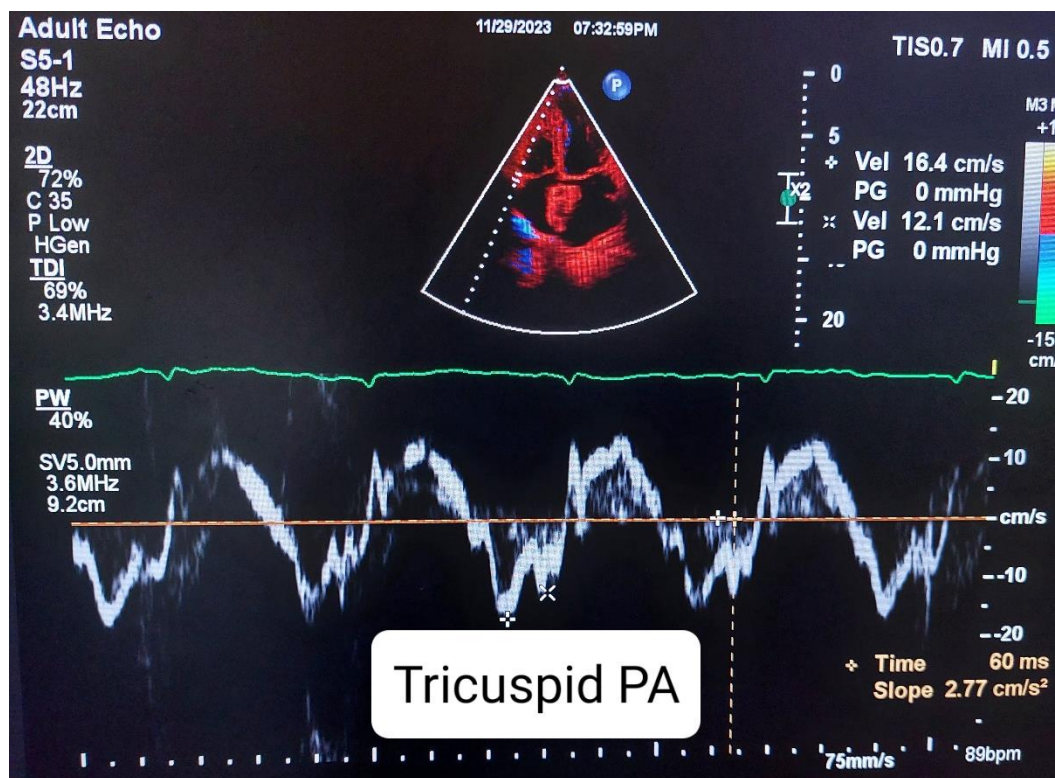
The evaluation of atrial conduction times using Doppler echocardiography.
